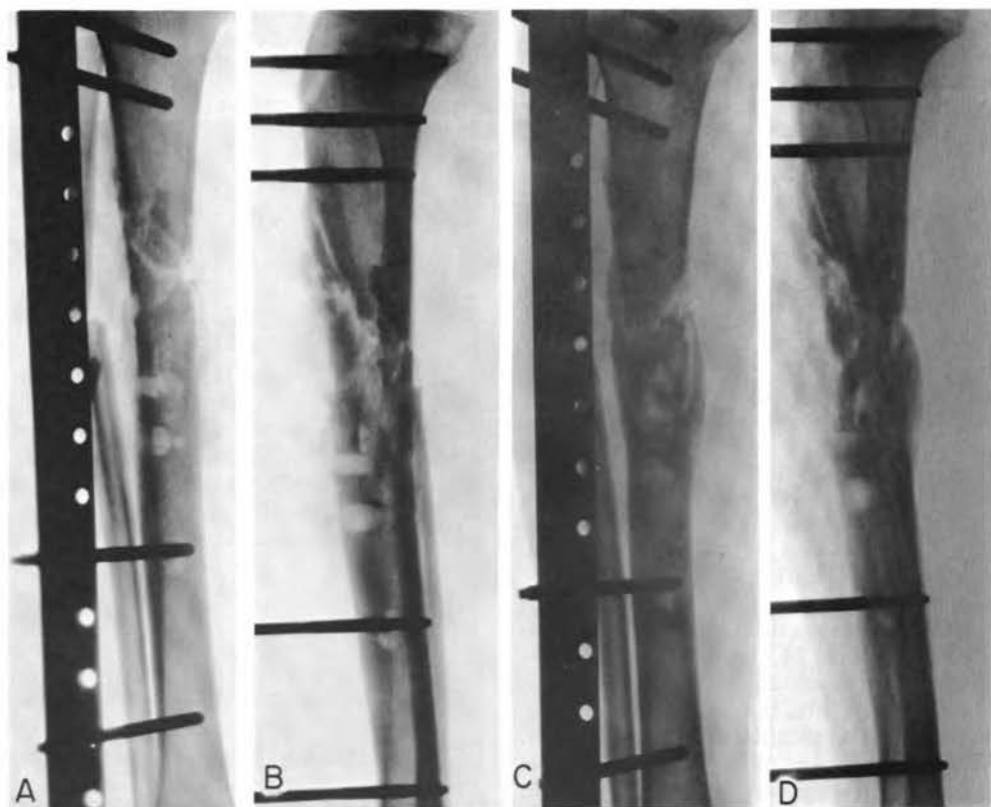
Case 4. A and B, x-ray appearance of infected left tibial and fibular fractures in February 1965, showing minimal callus formation and nonunion of bone. C and D, x-ray appearance 3 months after completion of OHP therapy and after infection had cleared (May 1965). Note callus formation and consolidation.
